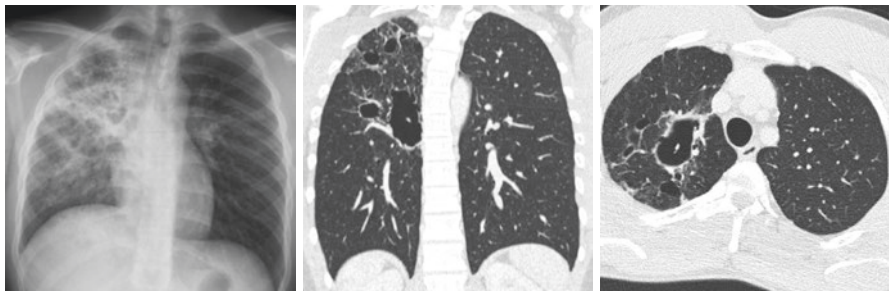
CXR and CT showing cavities in the right upper lobe
